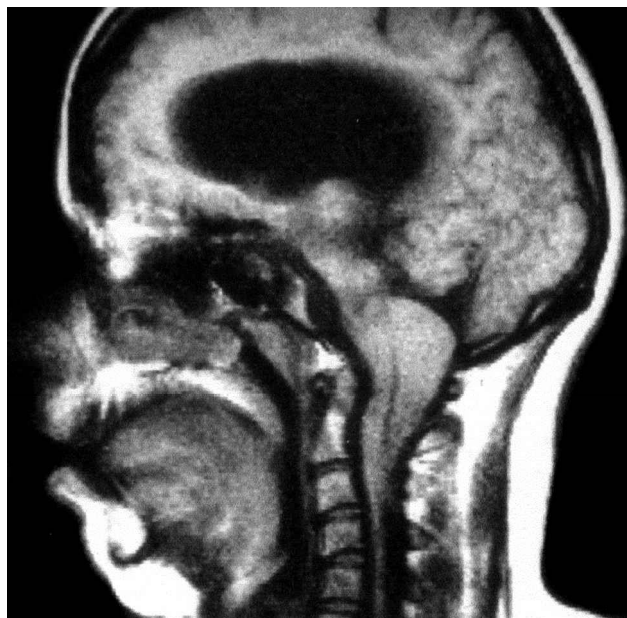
MRI of the brain and cervical spine in a patient with a typical Chiari II malformation. The brainstem and cerebellar tissue are displaced downward through the foramen magnum into the upper portion of the spinal canal.
